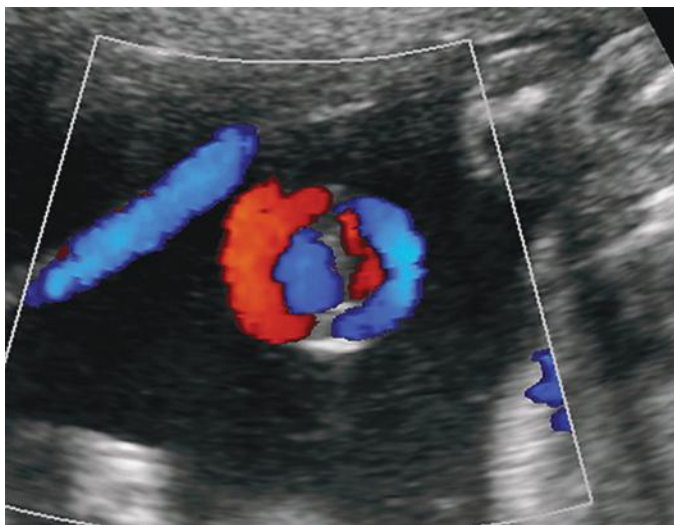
Umbilical cord knot suggested by color Doppler sonography at 22 weeks' gestation.
